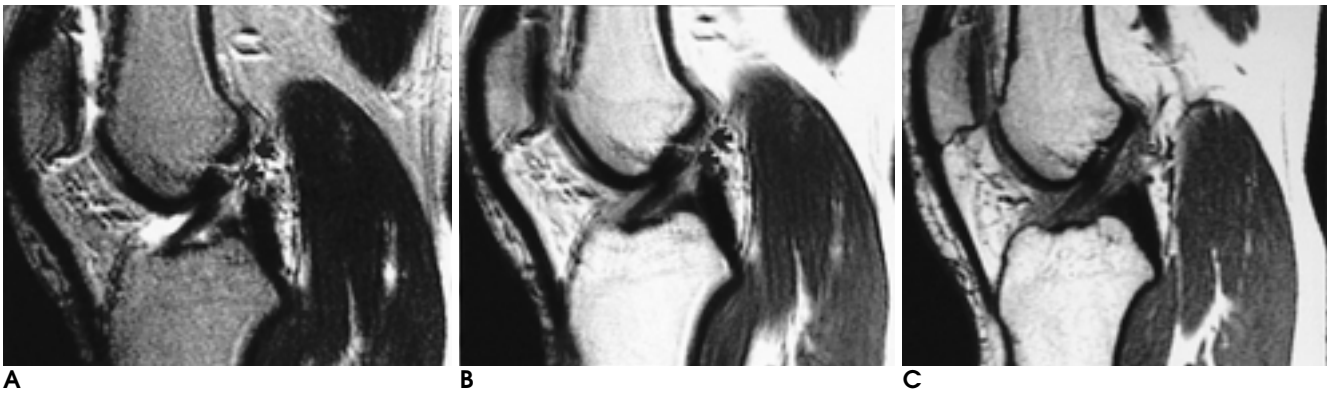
Normal anterior cruciate ligament mimicking tear on conventional MRI.
